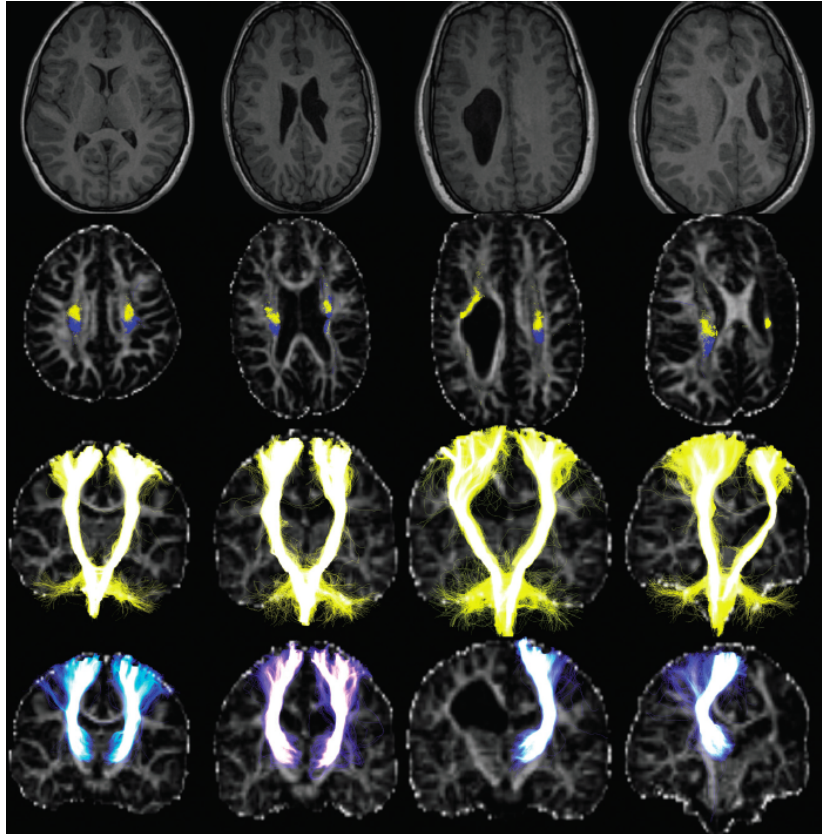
Tracking results of the CSTs (yellow) and the TRS (thalamic projections to the somatosensory cortex) (blue) in a healthy control (column 1) and 3 subjects with unilateral CP (columns 2– 4). Images, shown in radiologic orientation, include T1-weighted images (row 1) and tracts superimposed on FA maps in the axial section at the level of the upper corona radiata (row 2) and entire coronal projections (rows 3– 4). Subject on column 2 has a periventricular pseudocyst at the level of corona radiata, which causes local splits to the left TRS and left CST, which are seen to partly share locations, and dislocate the major branch of the left CST. Subject on column 3 has a large right WM lesion obstructing the anticipated courses of the TRS and the CST, making tracking of the TRS impossible and dislocating the right CST. Subject on column 4 had a left focal infarct with extensive damage to the entire left hemicranium and severe WM damage above the PLIC, which confined the left CST to a thin sliver of WM at the level of the corona radiata and made the left TRS nontrackable [30].
